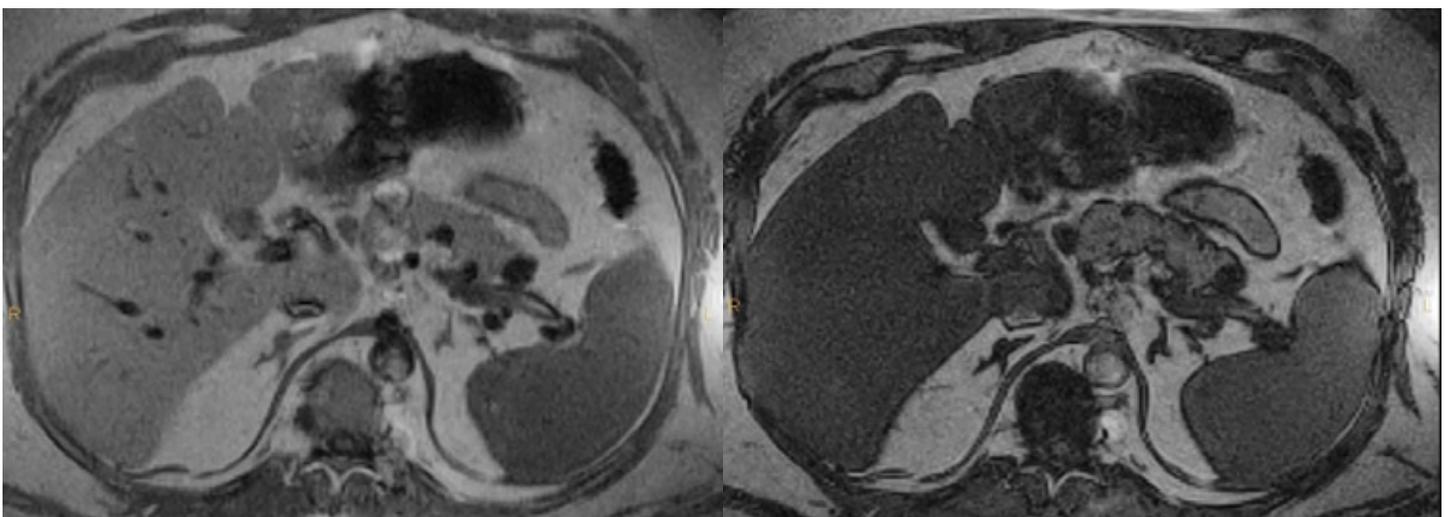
T1 in-phase MRI (left) and T1 out-of-phase MRI (right) of 55-year-old male shows diffuse liver signal loss on out-of-phase image.
